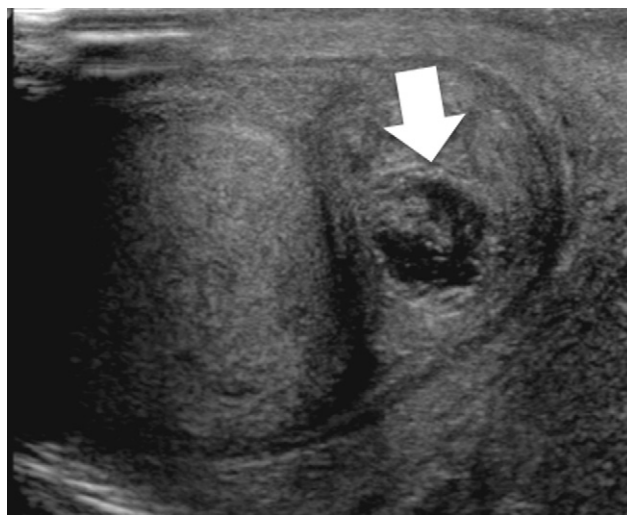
Abscess of the tail of the epididymis. B-mode sonography: highly hypoechoic collection with internal echoes (arrow).
